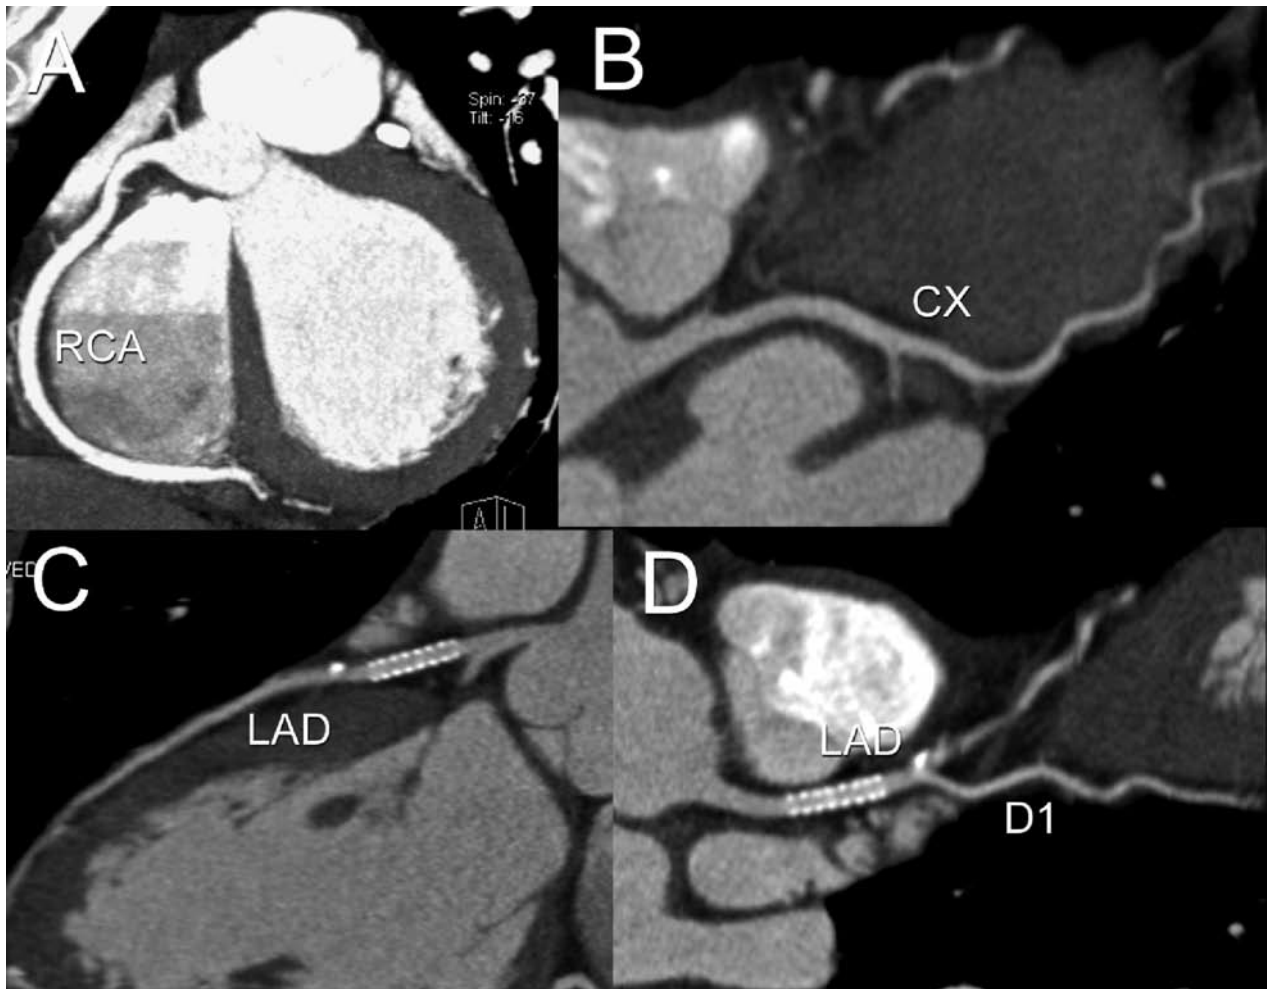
Example of CT-CA in patients with atypical chest pain after PCI on the LAD. In a patient with right dominance (A) and normal RCA and CX (A-B), the CTCA shows a stent in the LAD (C-D). The multiplanar reformats along the vessel length (C-D), show a clear and regular in-stent lumen.
